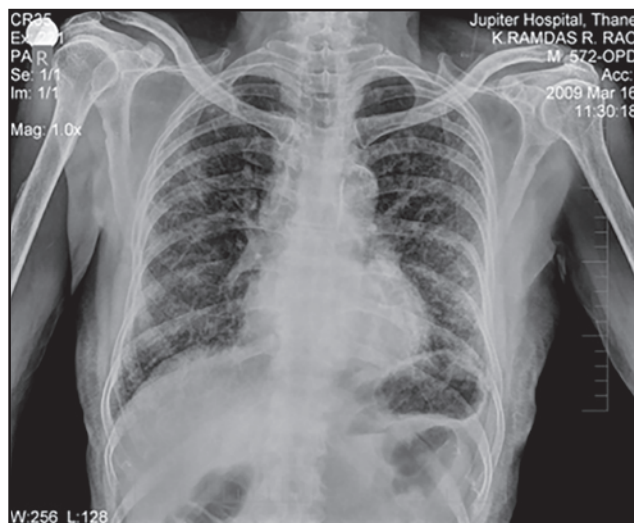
Chest radiograph showing bibasal reticulations, honeycomb changes and traction bronchiectasis.
